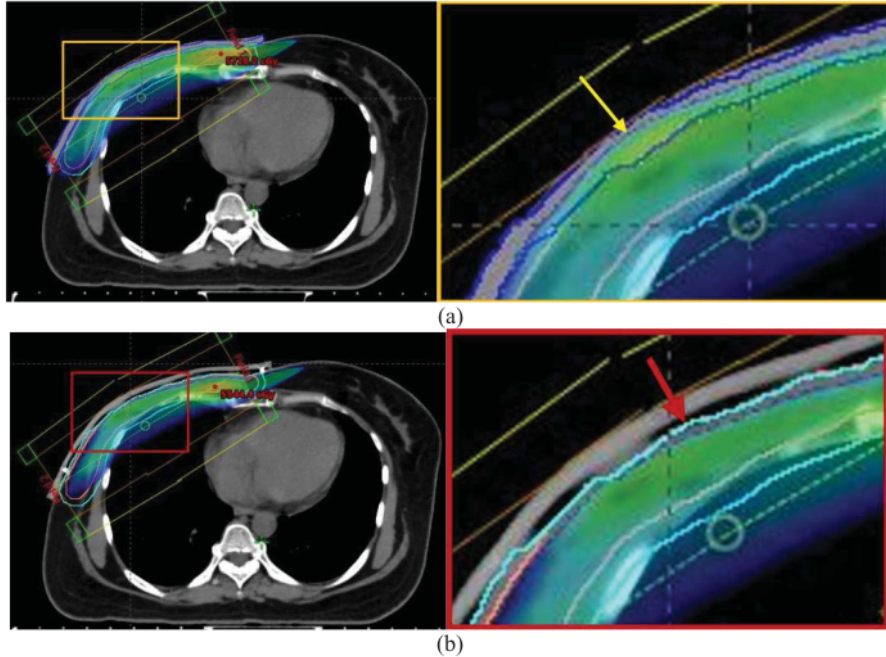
Pair of CT image slice for 3DCRT planning, (a) virtual bolus without airgap and 95% isodose line reach skin surface (yellow arrow), (b) Plasticine bolus with airgap and underdose area at the surface (red arrow).
